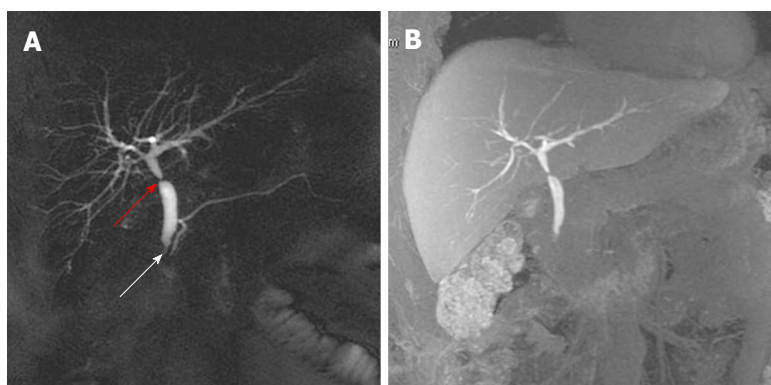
Anastomotic biliary stricture associated with sphincter of Oddi dysfunction. A: Single-shot thick-slab magnetic resonance cholangiogram shows stricture of both anastomotic site (red arrow) and juxta-papillary choledoch (white arrow), with dilation of pre- and post-anastomotic biliary tract; B: Maximum intensity projection reconstruction of Gd-EOB-DTPA enhanced T1-weighted LAVA sequence demonstrates regular excretion of contrast-enhanced bile in the extra-hepatic biliary tract at 20 min, while contrast-enhanced bile excretion in the duodenum is not appreciable.
